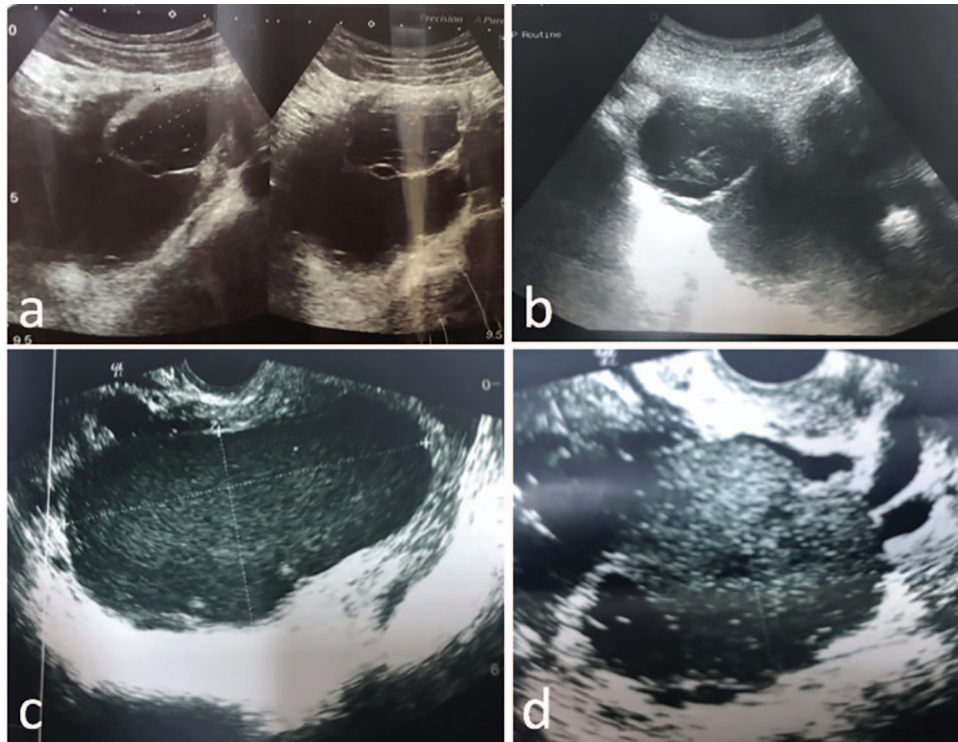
(A, B) Transabdominal, and (C, D) transvaginal sonographic images of Case 1. (A, B) Indeterminate adnexal mass; (C) endometrioma part of adnexal mass; (D) dermoid cyst.
